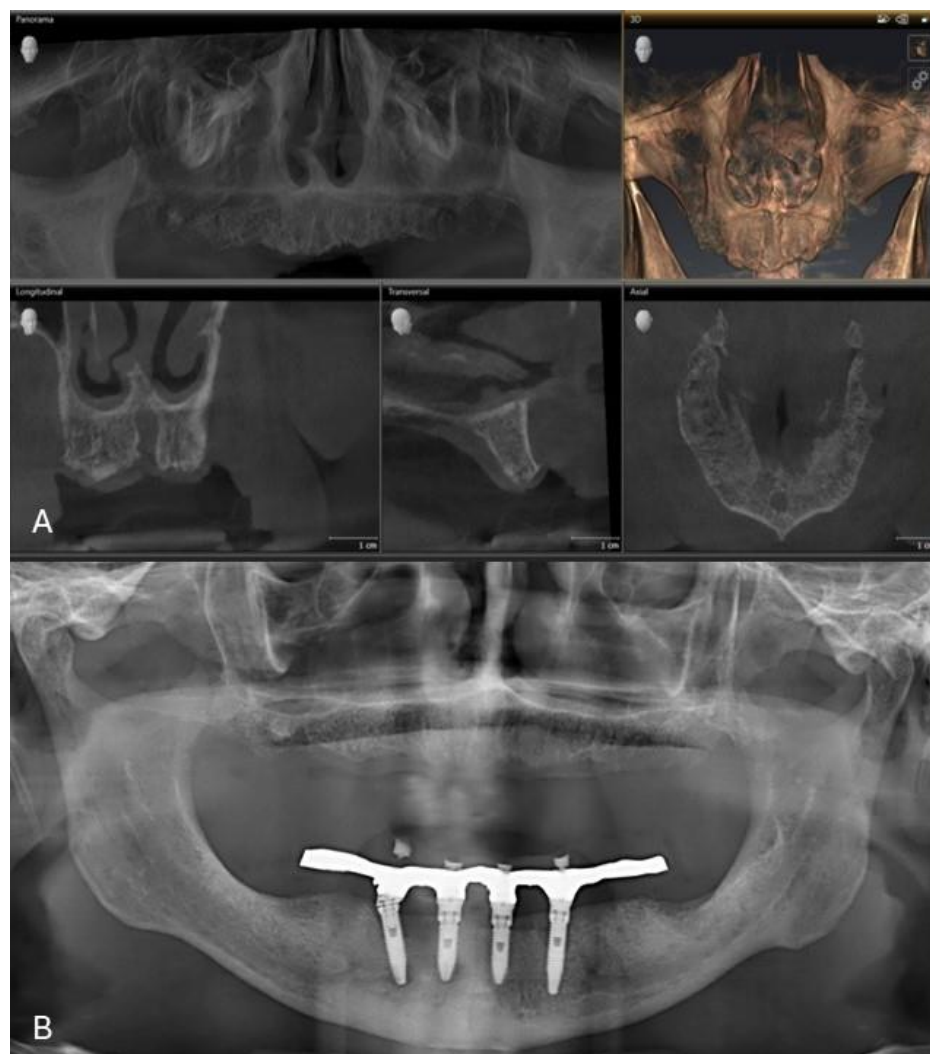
(A) Initial CBCT images. (B) Initial panoramic x-ray.
